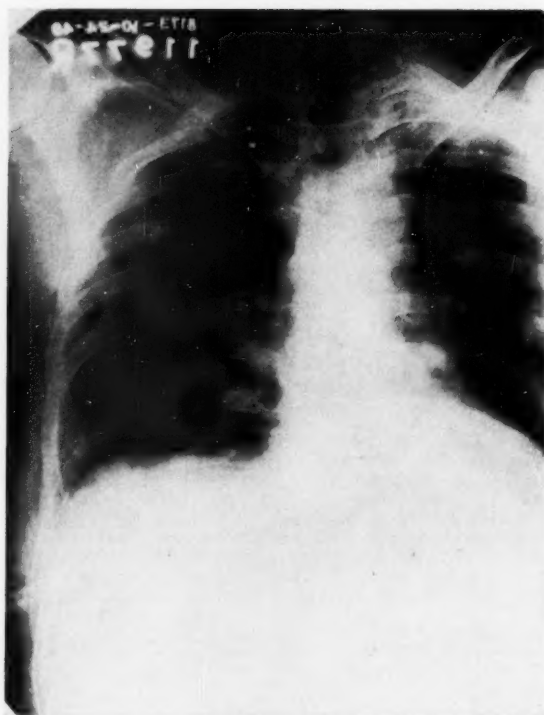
Chest x-ray of same patient (H. D.) on 151st hospital day following right lobectomy and drainage of small subphrenic abscess.
